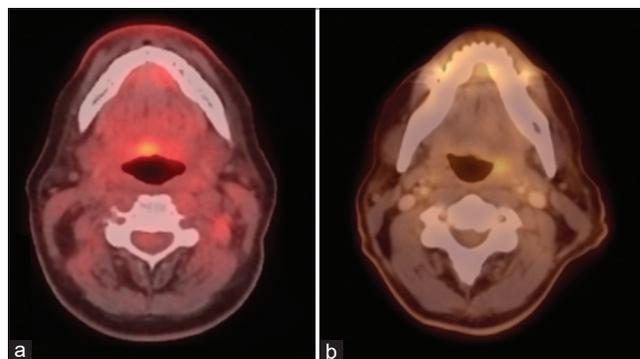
Examples of positron emission tomography (PET) avidity following proton therapy. (a) Patient with residual PET avidity in the base of tongue on post-treatment PET/computed tomography CT who was followed clinically and was without evidence of disease recurrence at last follow-up. (b) Patient with residual PET avidity in the left tonsil on post-treatment scan found to have residual/recurrent tumor that was surgically salvaged.
